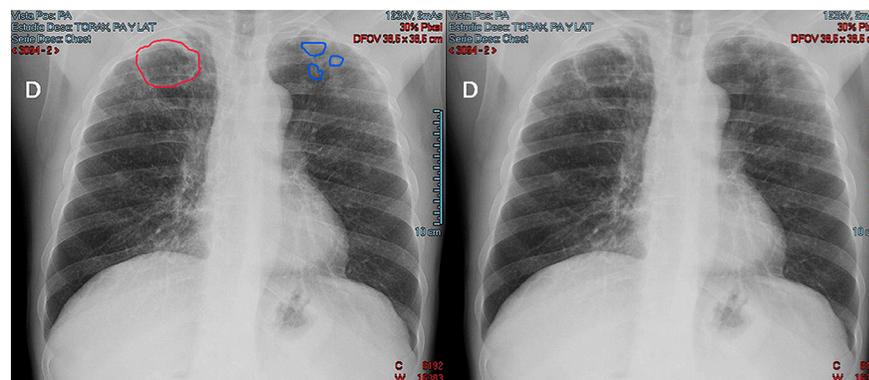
Chest X-ray: cavitated lesion in the apex of the right hemithorax and pseudo condensation images in the apex of the left hemithorax. The red line surrounds the cavitated lesion while the blue lines surround the pseudo condensation images.
